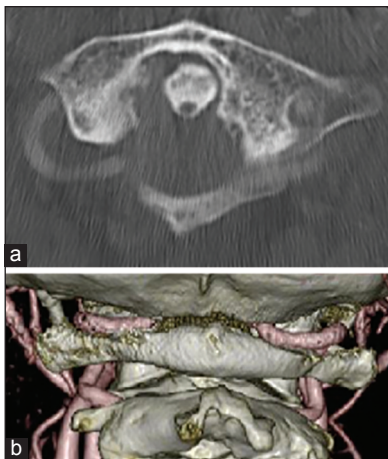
Axial and 3D computed tomography angiography (CTA) in Case 3 (a, b) showing posterolateral protrusion of the right vertebral artery (VA), whereas left VA was in the groove of the posterior arch of the atlas
